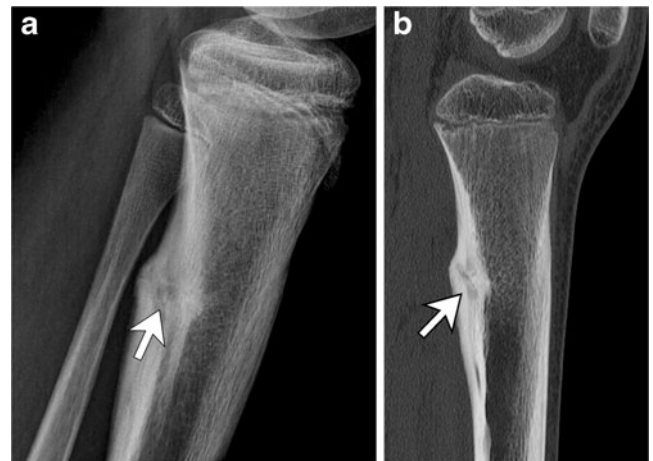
Images in a 11-year-old boy with right knee pain for 3 weeks and no known trauma. a Lateral radiograph of the proximal tibia demonstrates cortical thickening along the posterior diaphysis with central lucency and a more sclerotic appearance centrally (*arrow*), suggesting an osteoid osteoma. b Sagittal CT of the proximal tibial clearly shows a fracture lucency with surrounding callus (*arrow*)
